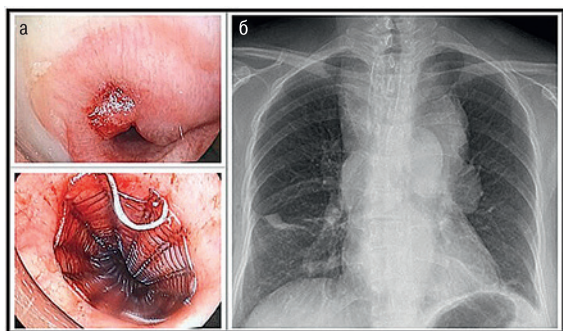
Bronchoscopy and post-bronchoscopy images: a – Tracheal narrowing with invasion and placed tracheal stent, b – Postoperative X-ray showing the tracheal stent in place
